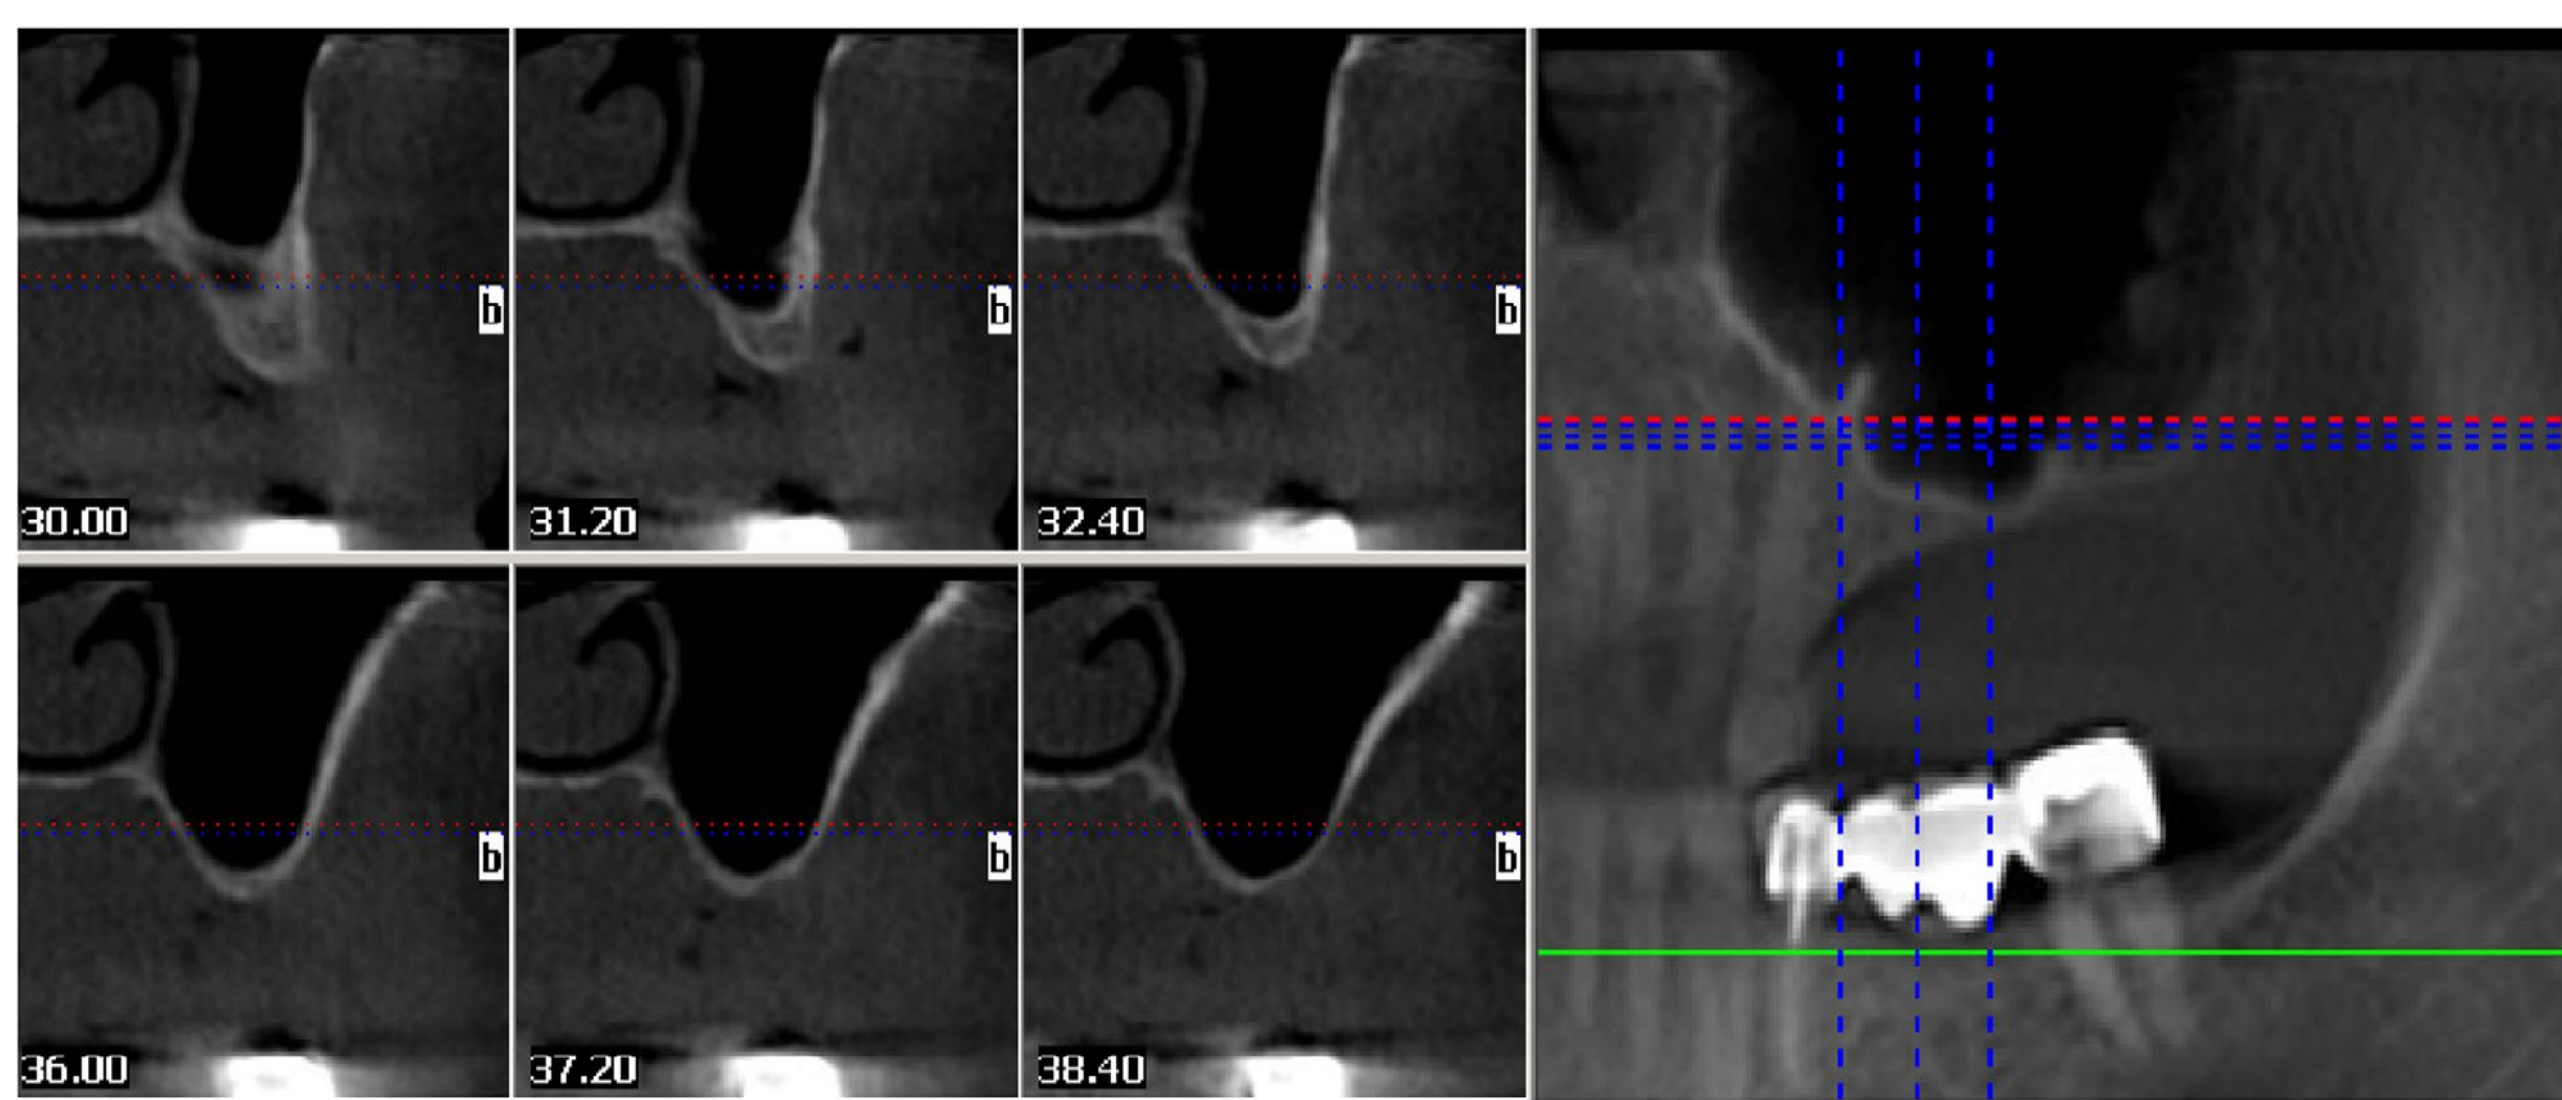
Preoperative CBCT of the upper left sinus area.
